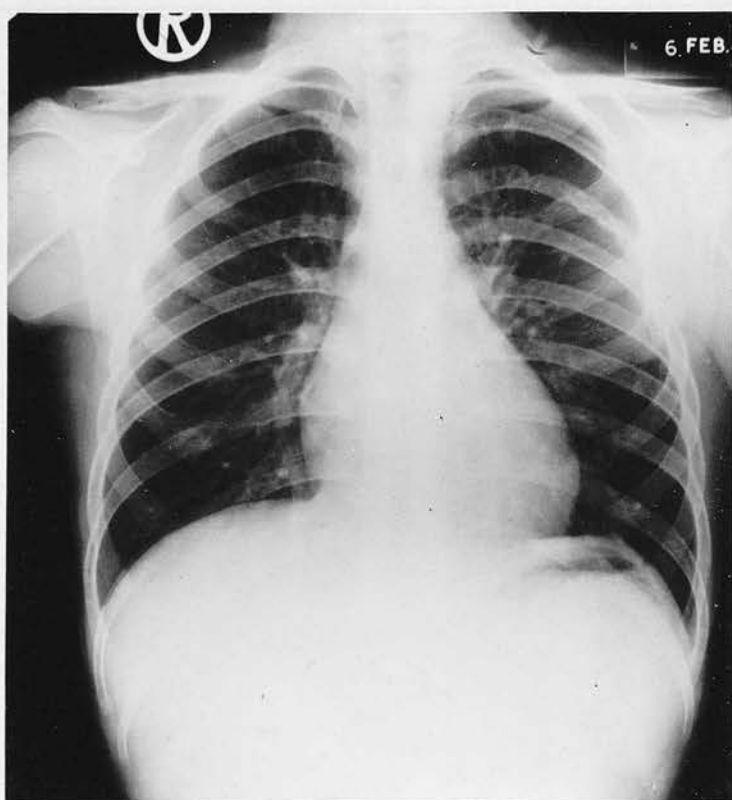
Radiograph of Case 62. Marked reduction in size of Pulmonary Artery following ligation of Patent Ductus Arteriosus at 7yrs.
